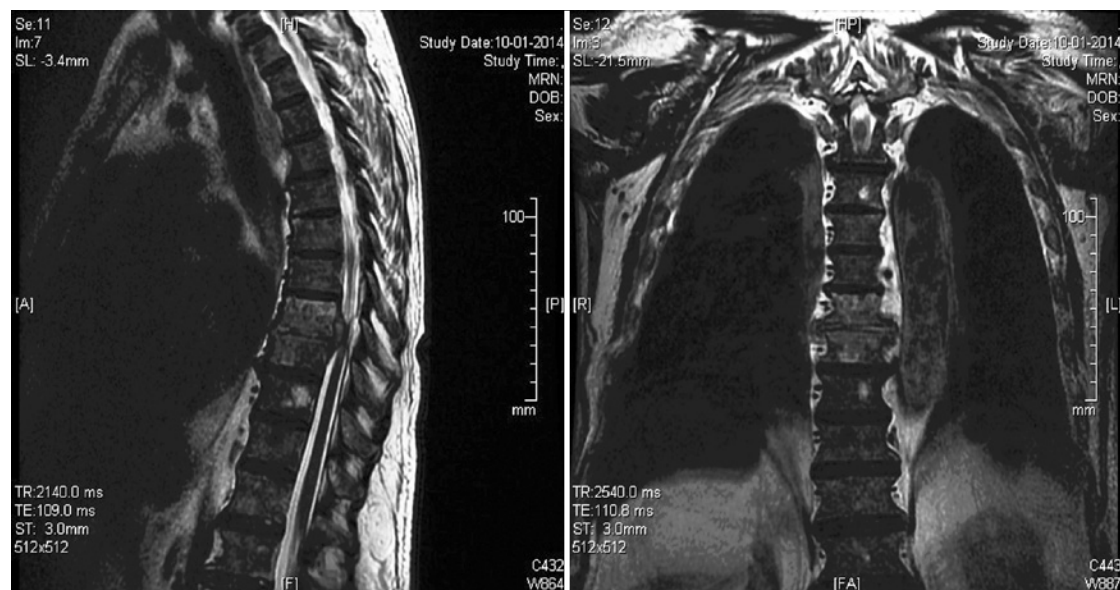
MRI presenting structural changes in the subchondral adjacent regions of D8-D9, with osteolytic and peri-vertebral inflammatory component, causing obliteration of the adjacent spinal subarachnoid space and molding the ventral medulla.
